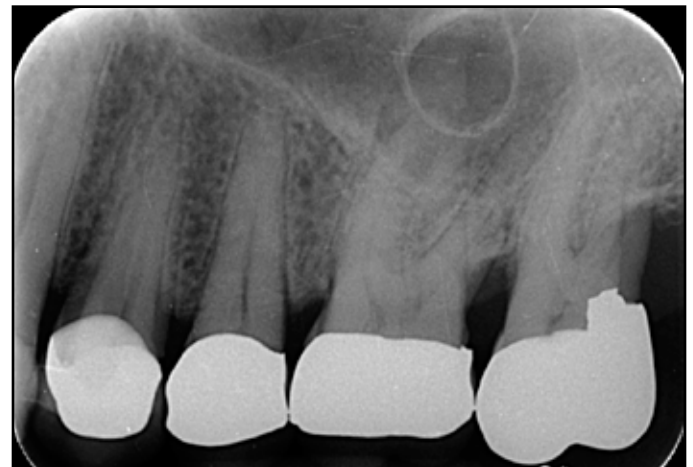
Periapical film of maxillary molar showing a circumscribed lesion apparently dissociated from this tooth. (G. Horn)
